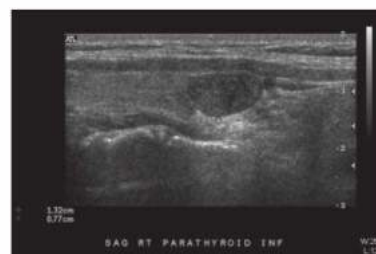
• High-resolution ultrasound image of 1.32 × 0.77 cm homogenous, hypoechoic mass inferior to the right lobe of the thyroid gland in a sagittal view. At operation, this was confirmed to be a right inferior parathyroid adenoma.
